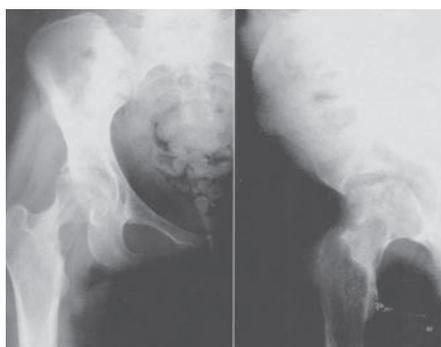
Hip X-ray image at baseline, showing a lithic injury at the lower region of femoral neck, and a flattening on the anterosuperior region of femoral head.
